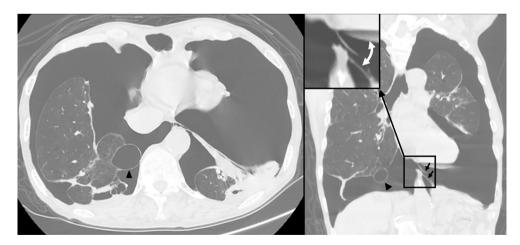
CT scan showing simultaneous bilateral pneumothoraces and a bulla in the right lower lobe (arrowhead), and bridging air space in the mediastinum, suggesting the presence of a pleural window connecting the two pleural cavities. The pleural window was shown in the coronal image more clearly than in the axial. There were membranes on the left side of the pleural window (arrows), and they might work like a flap, as shown by the double-headed arrow (square). CT, computed tomography.
